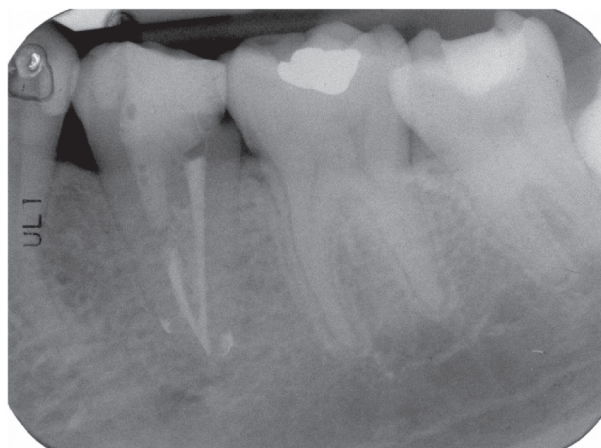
Radiographic image of the root-canal treated gemination tooth at one-year recall. The patient reported the tooth was asymptomatic. From the radiograph, the pre-operative PDL thickening was absent with normal intact lamina dura. However, the extruded sealers were still present. The defect at the gingival margin of restoration was observed, which was clinically secondary caries at the early stage.
